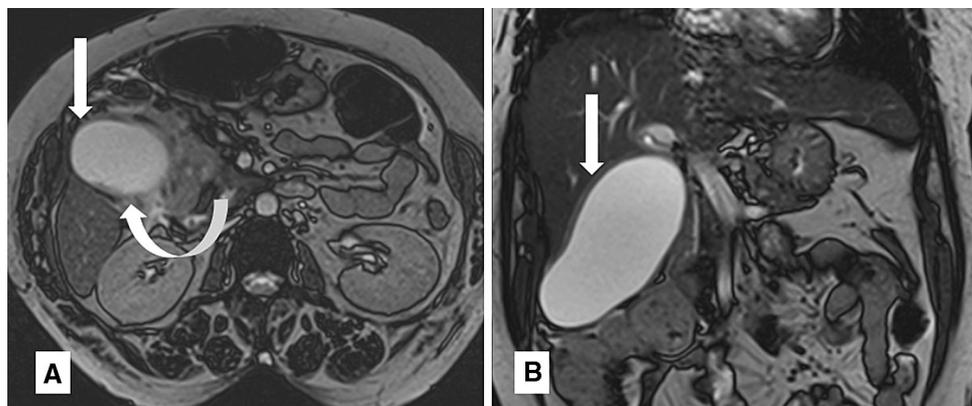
Axial MRI steady state gradient echo sequence image a shows distended non flattened gall bladder fundus indenting the overlying anterior abdominal wall (straight arrow) with gall bladder wall thickening (curved arrow).
